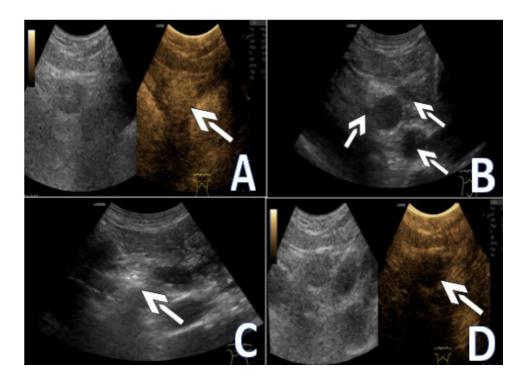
Microwave ablation of secondary hyperparathyroidism nodules in the upper mediastinum. Prior to ablation, the superior mediastinal tubercle was uniformly enhanced by contrast-enhanced ultrasound (A). A fluid isolation zone was injected around the nodule (B). Hyperechoic gas was covered when the nodule was completely ablated (C). Postablation contrast-enhanced ultrasound showed no perfusion of contrast agent (D).
